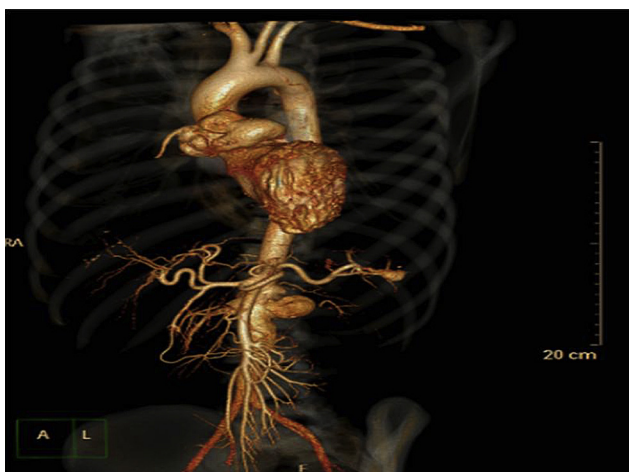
3D reconstructed CT angiography image of aorta and its branches. Note the dilatation of abdominal aorta at the level of renal artery.
